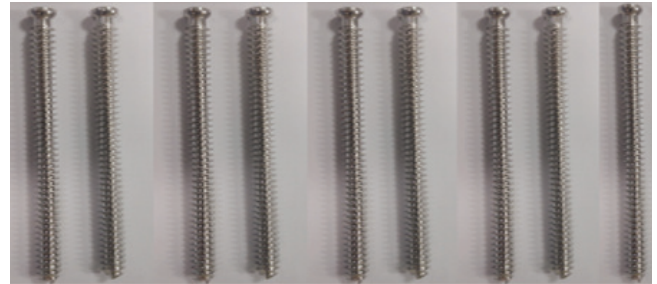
(b). Actual images of cannulated screws after ultrasonic cleaning
